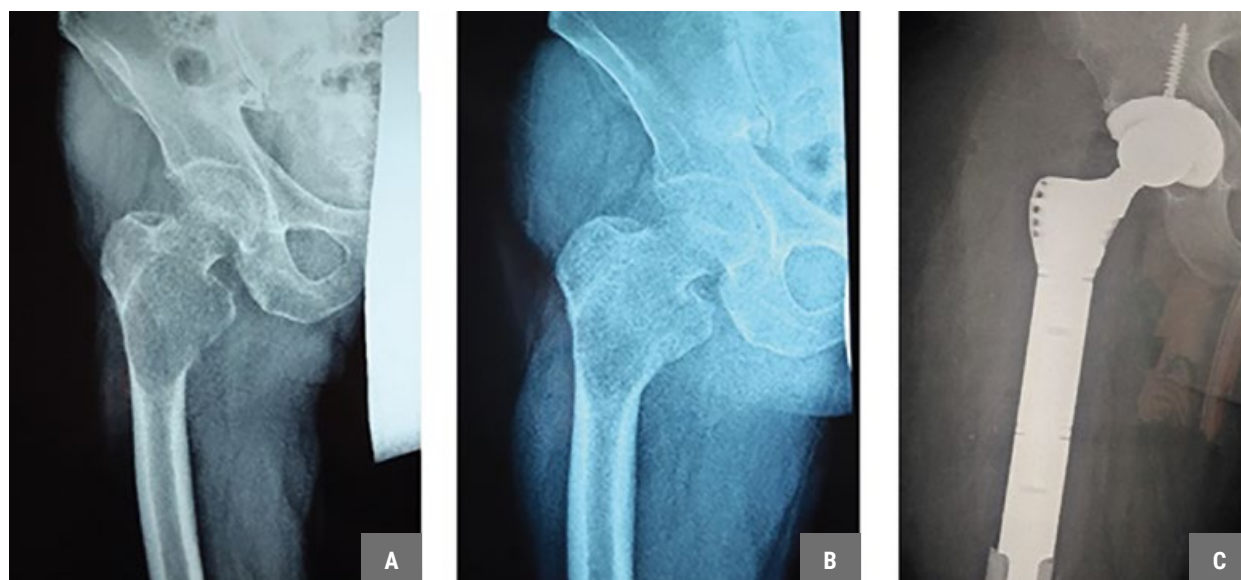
x-Ray images of the patient. A – before the start of neoadjuvant therapy with denosumab, signs of osteolytic formation of the proximal part of the right femur, pathological fracture. B – after completion of neoadjuvant therapy with denosumab, sclerosis of the focus of lytic destruction, signs of consolidation of the pathological fracture. C – condition after segmental resection of the upper third of the right femur with a tumor, replacement of the defect with a hip replacement.
